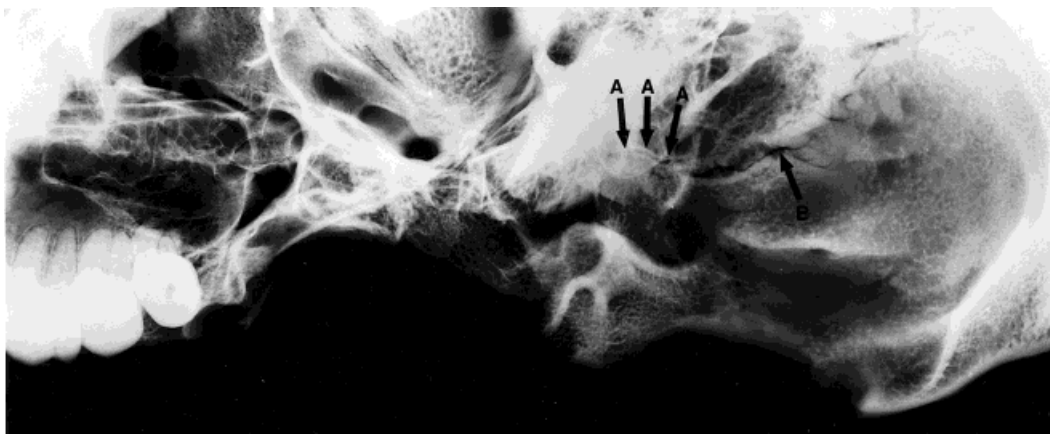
Superolateral radiograph view of HTH 1228 (white male, 20 years of age) with the petroexoccipital articulation open (A). B, occipitomastoid suture.
